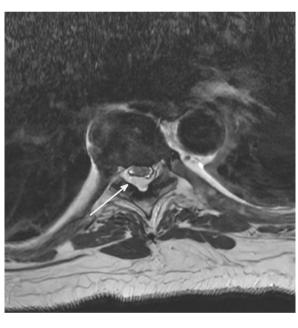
MRI T-spine: Thoracic Epidural Abscess extends entire length of the thoracic spine with both dorsal and ventral involvement (dorsal greater than ventral). At multiple levels from T1-T2 down to T5-T6, there is complete effacement of CSF surrounding the cord.
